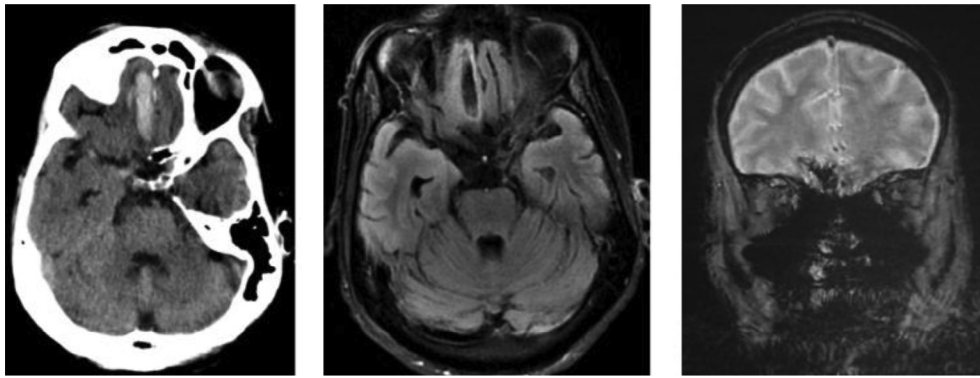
CT head, MRI brain T1 and GRE sequences showing hemorrhage in right frontal base with adjacent edema.
